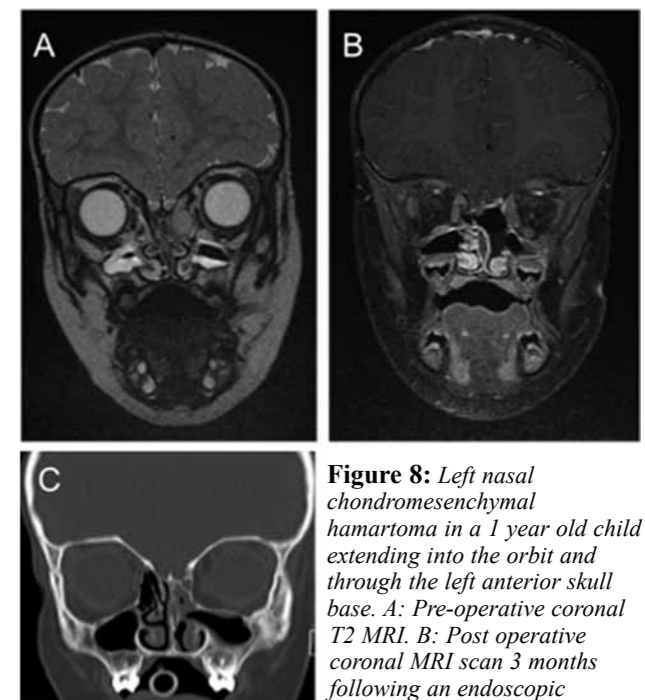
Left nasal chondromesenchymal hamartoma in a 1 year old child extending into the orbit and through the left anterior skull base. A: Pre-operative coronal T2 MRI. B: Post operative coronal MRI scan 3 months following an endoscopic craniofacial resection of the nasal chondromesenchyma and repair with a nasoseptal flap. C: Coronal CT scan 2 years post surgery. Regrowth of the cribriform plate and lamina papyracea is clearly evident.
